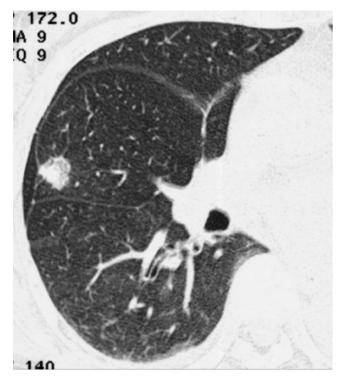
Bronchioloalveolar carcinoma in a 60-year-old woman. Thin-section CT obtained at the level of the bronchus intermedius shows a peripheral pulmonary nodule with the CT halo sign.
